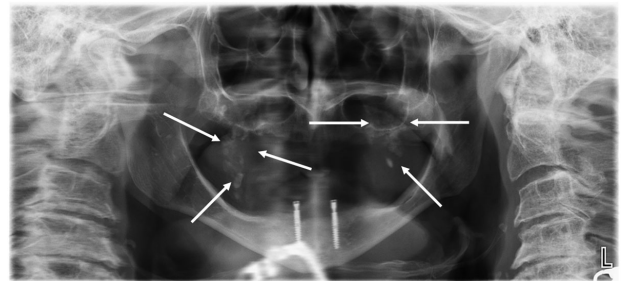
Panoramic radiograph obtained at initial consultation appointment showing radiopacities (arrows used to localize reader's focus).
